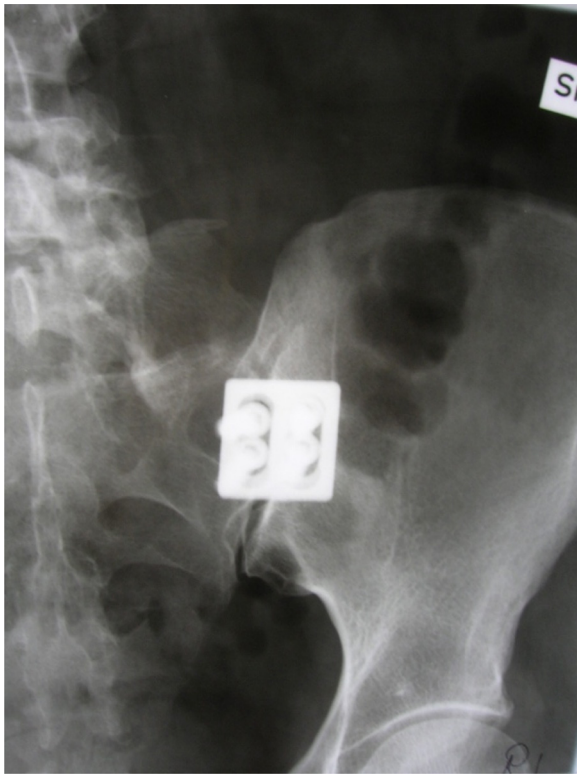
X-ray, anteroposterior view of plate fixation in anterior arthrodesis of the SI joint.
